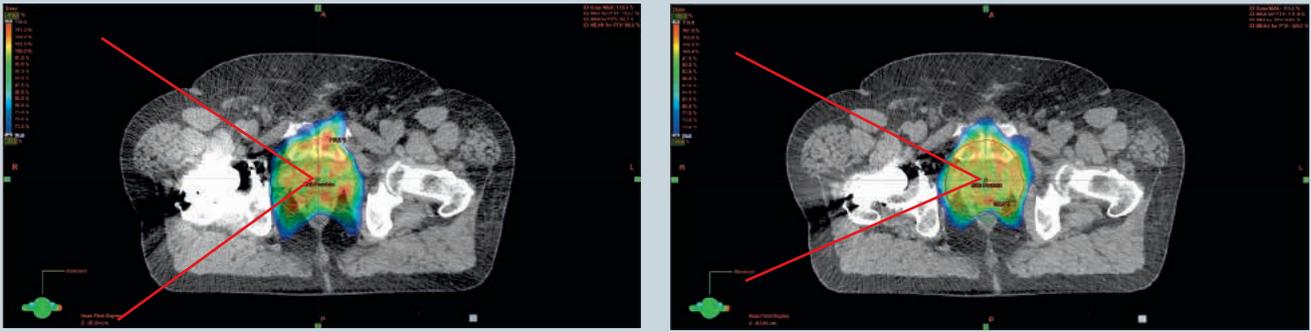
Display of the dose distribution with 6 MV photons in the Eclipse (Varian) planning system. The angle element between the red lines is not accessible for RapidArc optimization due to metal artifacts. Left side: the dose distribution of the 120 kV standard CT scan with an excluded angle of $\sim 80^\circ$. Right side: 120 keV DE Monoenergetic leads to a significant reduction of the previously excluded segment.
